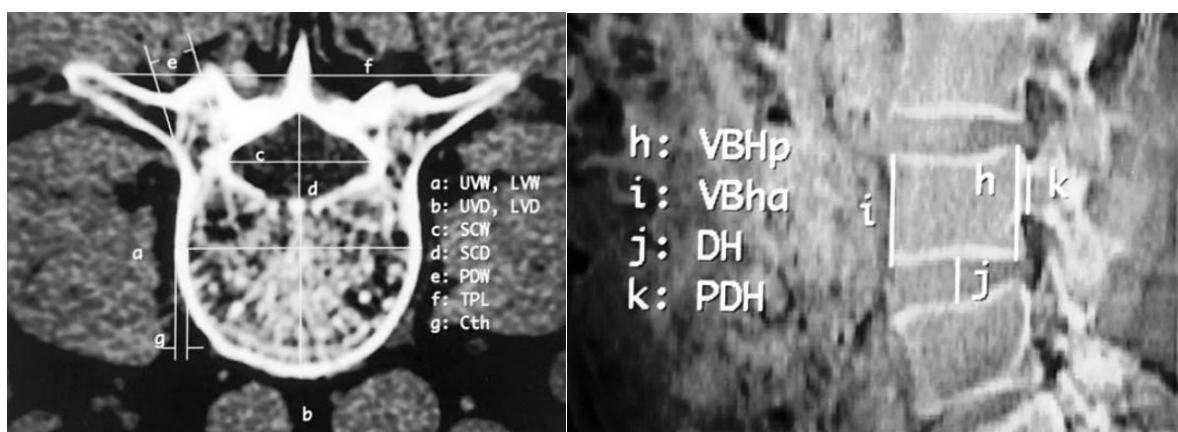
A cross-sectional image (left) and a lateral computed tomographic (CT) (right) of the fourth lumbar vertebral body (*UVW* upper vertebral width, *LVW* lower vertebral width, *UVD* upper vertebral depth, *LVD* lower vertebral depth, *SCW* spinal canal width, *SCD* spinal canal depth, *PDW* pedicle width, *TPL* transverse process length, *Cth* cortical bone thickness, *VBHp* vertebral body height posterior, *VBHa* vertebral body height anterior, *DH* disc height, *PDH* pedicle height). (Image source: S.H. Zhou (90))
